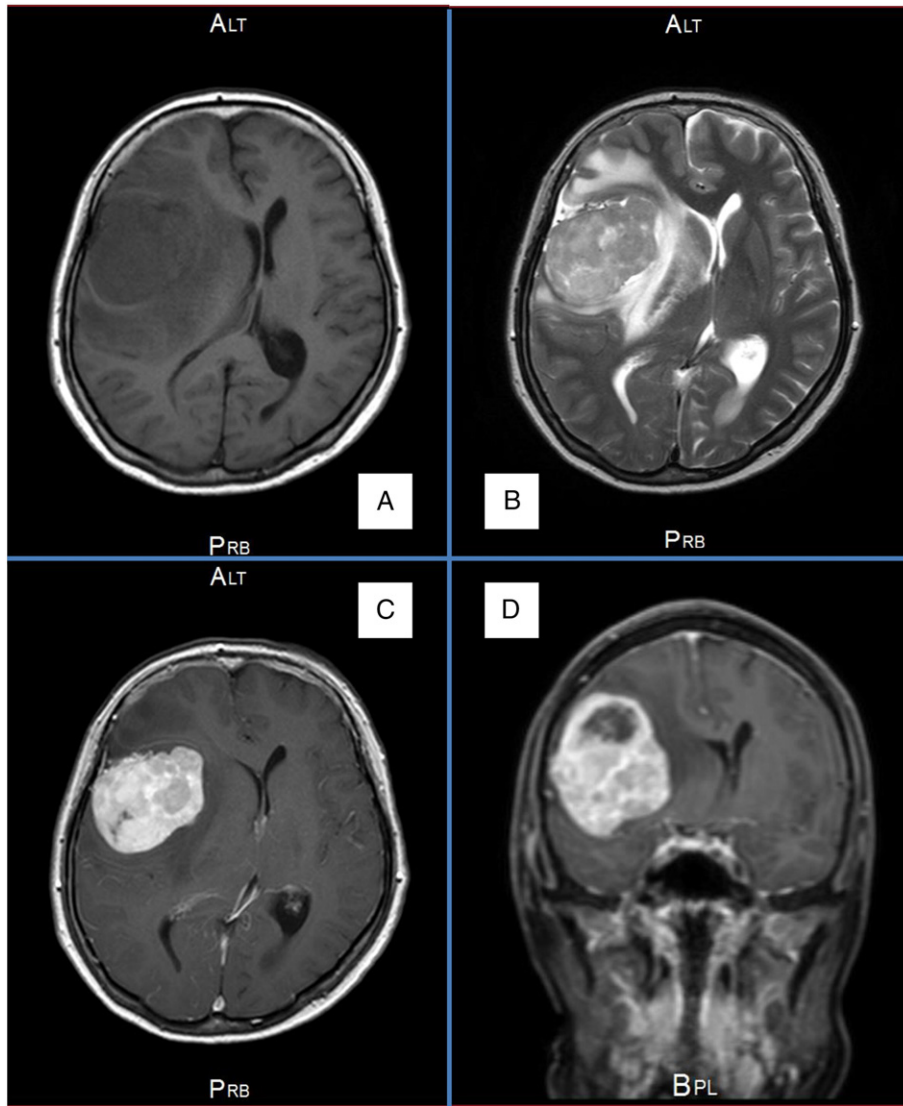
MRI images of the solitary brain metastatic lesion in the right frontal lobe. A: T1 image, B: T2 image, C and D: Gadolinium-enhanced MRI.
